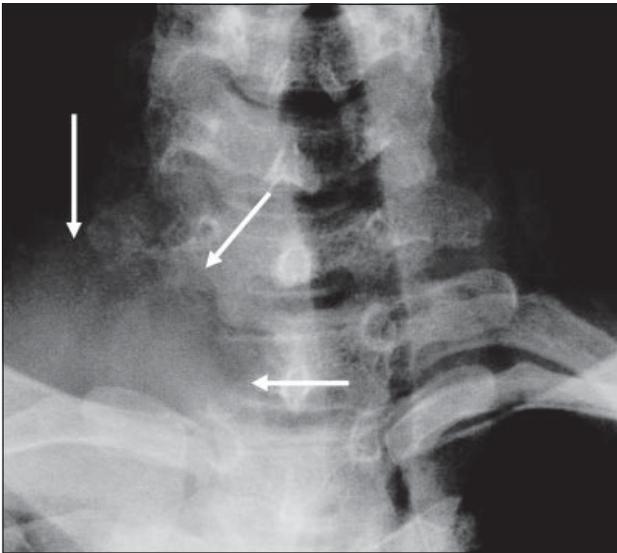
Frontal radiograph of the cervical spine demonstrates the extent of bony destruction of the right first rib and first thoracic vertebra.
